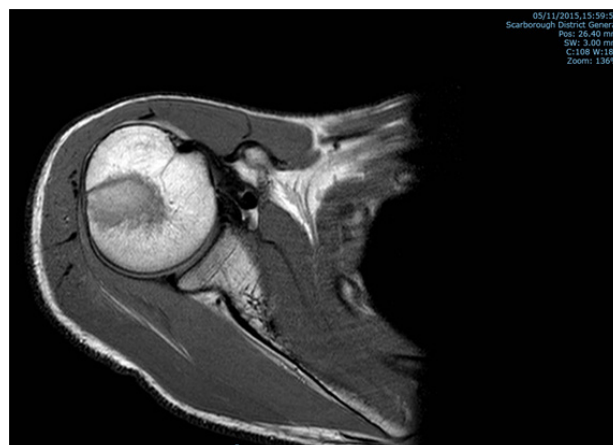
MRI of right shoulder joint.
